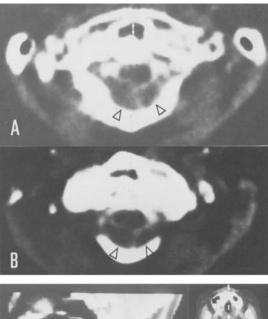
CT metrizamide myelography (CTMM) of Chiari malformation at level of C1 (A), C2 (B) and its sagittal reconstruction (C). In A and B, metrizamide clearly delineates cerebellar tonsils (open arrow heads) and the cord. Anterior dislocation of anterior arch of atlas from the dens (white arrow in A) indicates atlanto-axial dislocation. The CT-slices were sectioned parallel with "foramen magnum line" (-10° from RBL). In C, elongation of cerebellar tonsils below the foramen magnum (black arrow) and basilar impression are observed (Case 38. 44-year-old female).
